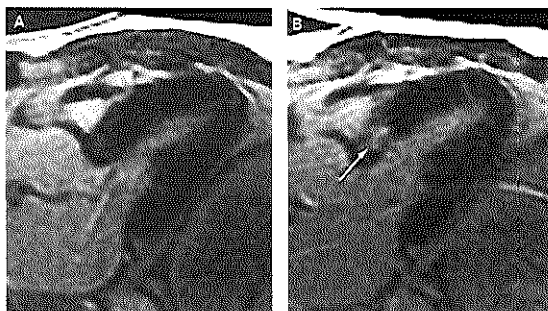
Gadolinium-enhanced MRI scans. (A) Scan taken before coil implantation. (B) Scan taken 48 h after coil implantation, demonstrating that infarction was confined to the basal anteroseptum (mass 8.1 g; volume 7.7 ml). White arrow shows the infarcted basal septal vessel.
